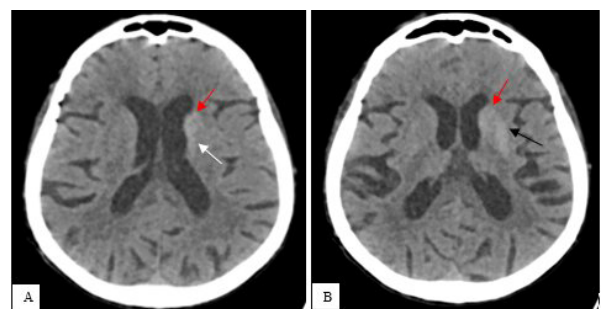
Head CT showing subtle abnormal hyperdensity involving the left striatal regions; The head of caudate nucleus (a,b; red arrow), the body of caudate nucleus (a,white arrow) and putamen (b, black arrow)
